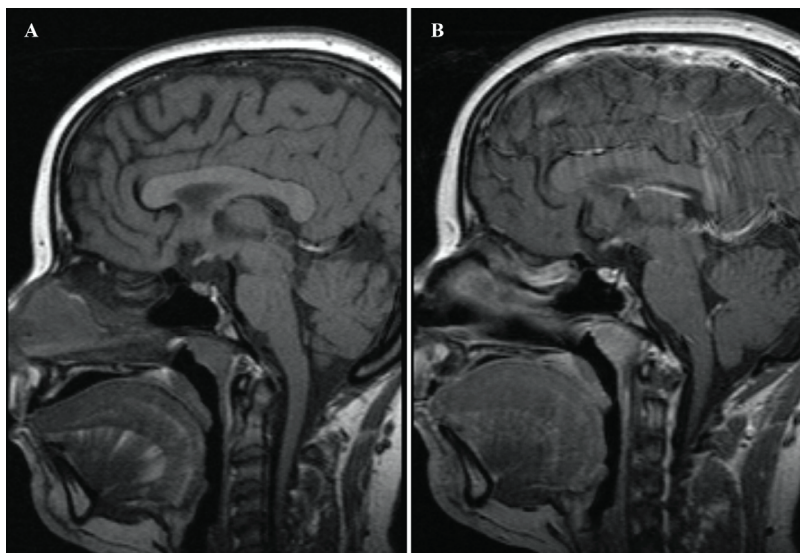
A & B) Sagittal T1-weighted images with and without contrast injection through the sella demonstrate loss of the normal bright spot of the neurohypophysis and an absent pituitary stalk.
